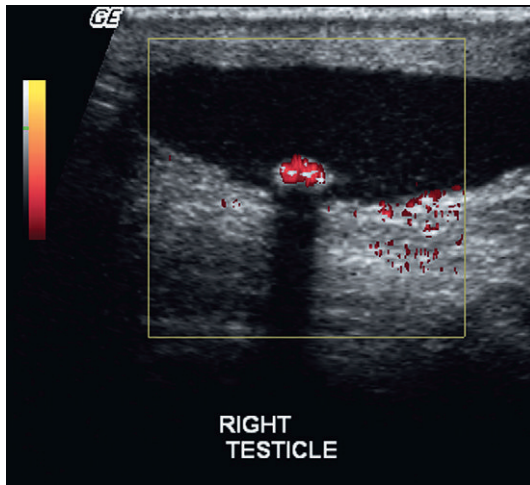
Image at the base of the right scrotum, distant from the testicle itself. An echogenic structure with acoustic shadowing is layering dependently. Power Doppler reveals colour emanating from this structure indicating frequency shift. This is consistent with twinkle artifact produced when the Doppler beam interacts with crystalline material on this calcified left scrotal pearl.
